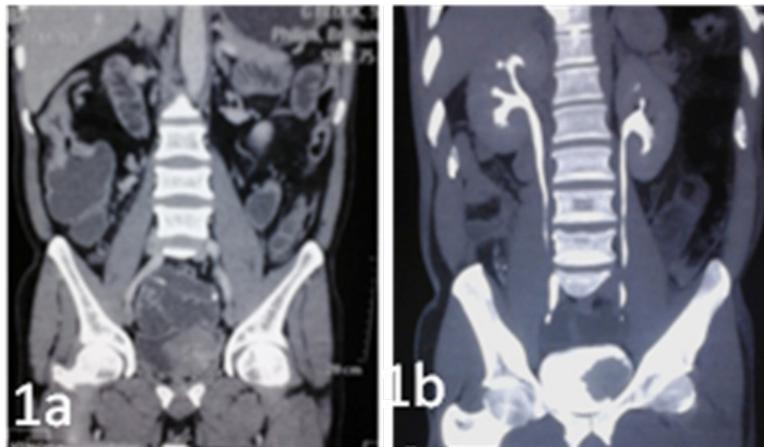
& Figure 1b: CT Urogram.
